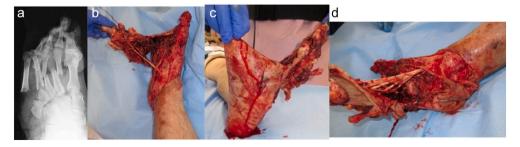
a: A-P X-ray of the foot. b/c/d: initial appearance of the foot in the operating room.
